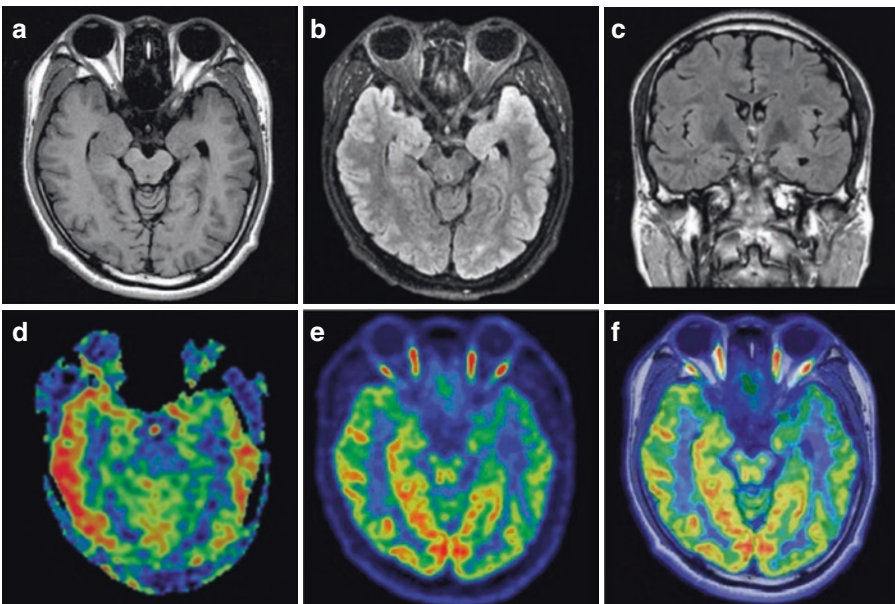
^{18}F -FDG PET/MR of epilepsy patient. A 23-year-old male patient suffering from epileptic seizures for 20 years. Transverse T_1 -weighted MRI (a), T_2 -FLAIR (b), and coronal T_2 -FLAIR (c) show enlarged left temporal horn, and smaller left hippocampal volume compared to the right with slightly higher signal intensity. ASL shows lower
